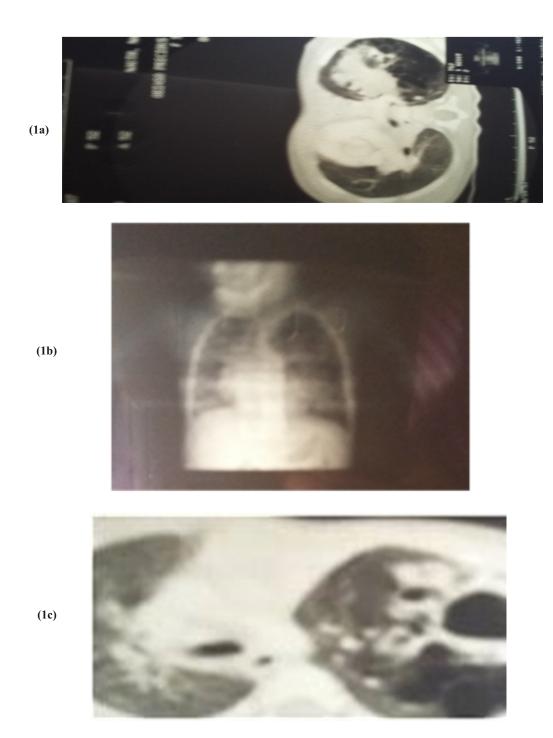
(a, c) Computed tomographic scan of the chest showing multiple, well defined, rounded air dense lesions of varying sizes within the left hemithorax with associated ring enhancing. (b) Chest radiograph revealing multiple thick walled cystic lesions within the left hemithorax.
